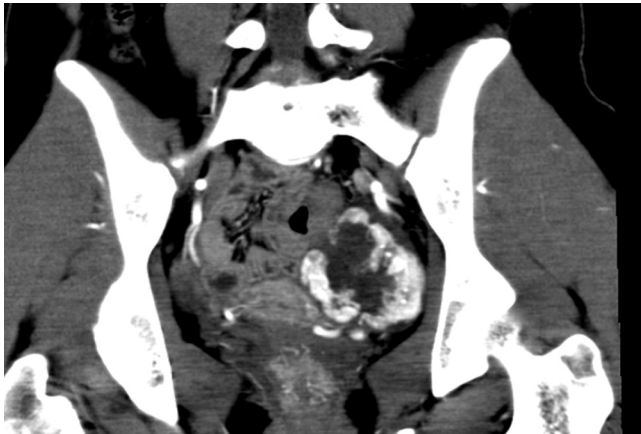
Contrast-enhanced CT shows a left ovarian tumor with early peripheral enhancement reflecting hypervascularity.
